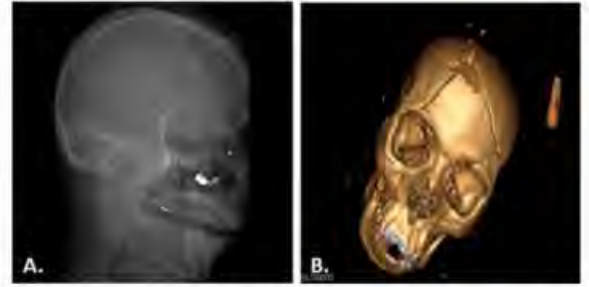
(A) Radiograph of a patient with perforating cranial gunshot injury. Entry wound was identified at the hard palate while the exit wound was through the frontal bone. (B) 3D reconstruction of the same patient's head CT scan shows comminuted fracture of the frontal bone at the exit wound with extension of fractures to the bilateral orbital roof.
